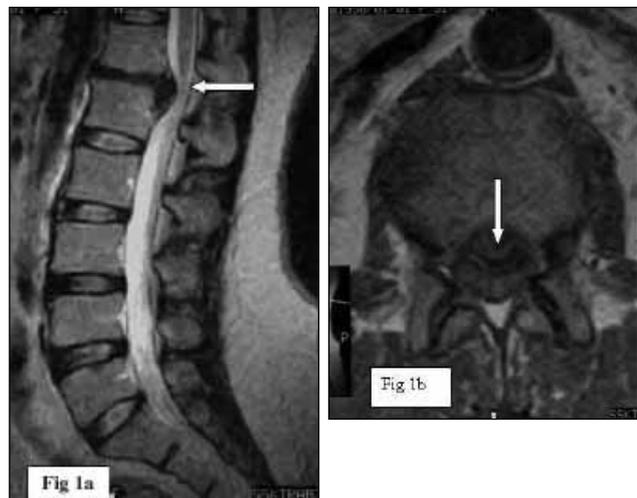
Magnetic resonance imaging of case 18: Sagittal (1a) and axial (1b) T2-weighted MRI demonstrated complete spinal canal stenosis due to a massive disc herniation at the T12-L1 level. The disc fragment had migrated posterior to the sack (arrows).
